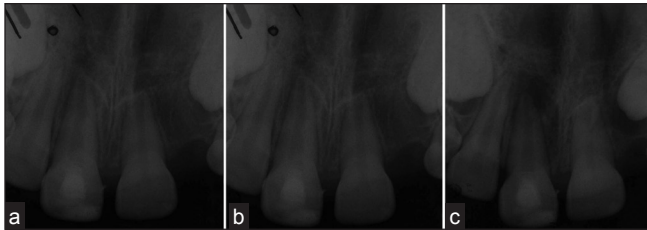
Intra-oral periapical radiograph: (a) 3 months follow-up, (b) 6 months follow-up and (c) 12 months follow-up showing continued root development
